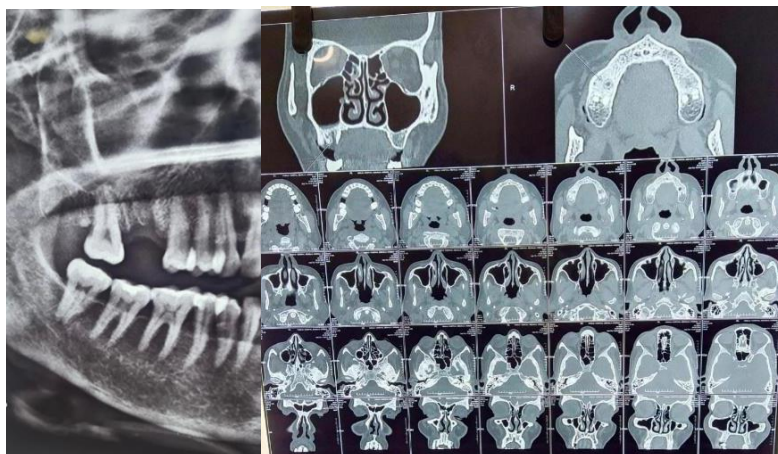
OPG and CT picture of OAF
